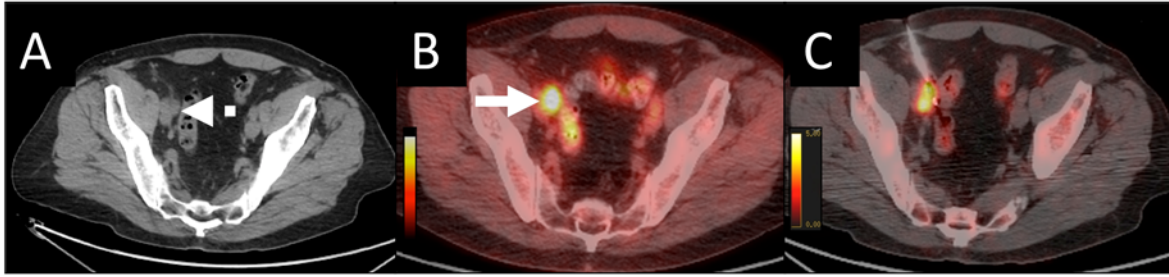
Delayed molecular imaging PET/CT-guided biopsy of a lymph node metastasis of prostate carcinoma
